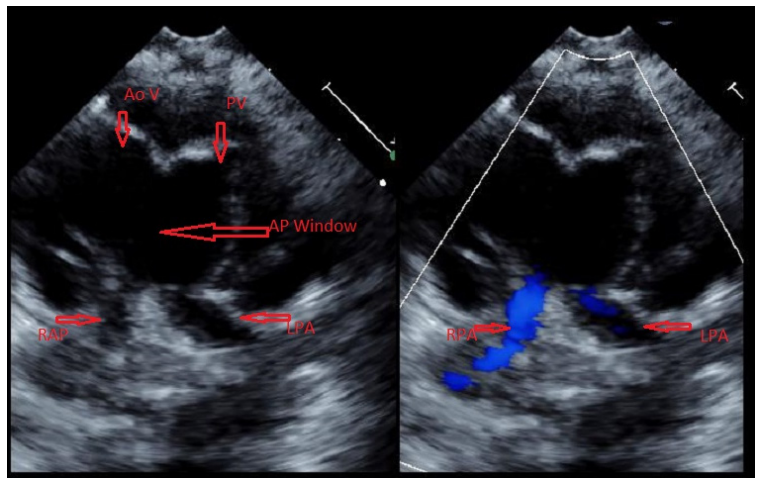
Parasternal short axis echocardiogram image on color comparison showing large aortopulmonary window with both branch pulmonary arteries coming off posterior portion of common trunk. (RPA-Right pulmonary artery, LPA-Left pulmonary artery, AoV-Aortic valve, PV-Pulmonary valve, AP Window-Aortopulmonary window).
